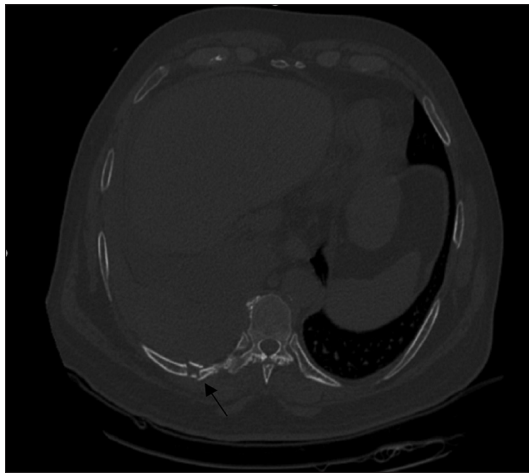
Axial computed tomography bone window image showing fracture of the right ninth rib (black arrow)
